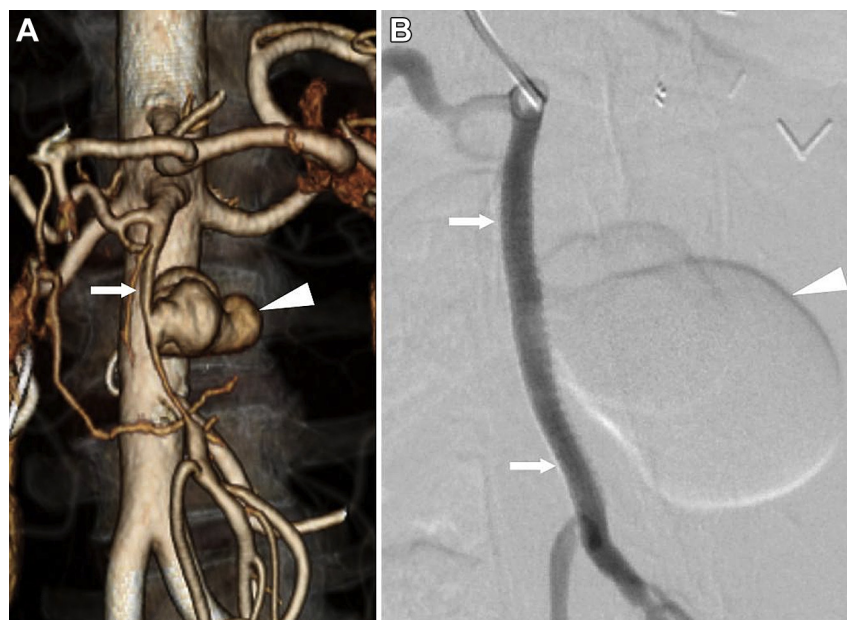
A 64-year-old male with acute pancreatitis presented with acute abdominal pain. (A) Contrast-enhanced computed tomography coronal volume rendered technique reformatted image showing a pseudoaneurysm (arrowhead) arising from the superior mesenteric artery (SMA, arrow). (B) As the SMA is not expendable, isolation of pseudoaneurysm achieved by deploying a covered stent across the neck of pseudoaneurysm (arrows). Postprocedure the SMA is patent and the pseudoaneurysm completely isolated (arrowhead).
